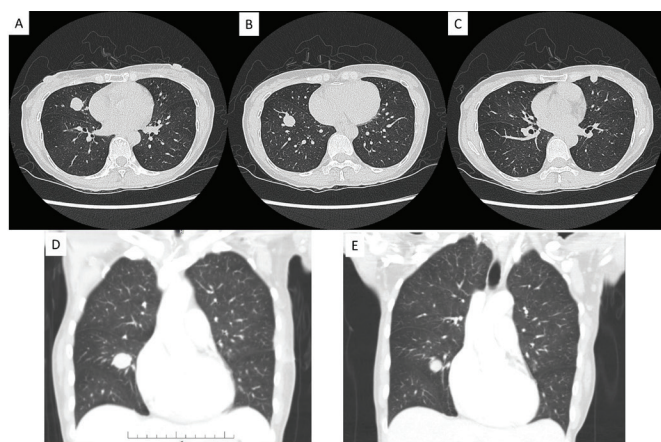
A CT scan demonstrates three bilateral lung nodules, in right middle (A) and lower lobes (B) and in left upper lobe (C). Ensuing CT scans highlights almost minimal interval change of right middle (D), and lower lobe lung nodules (E).
